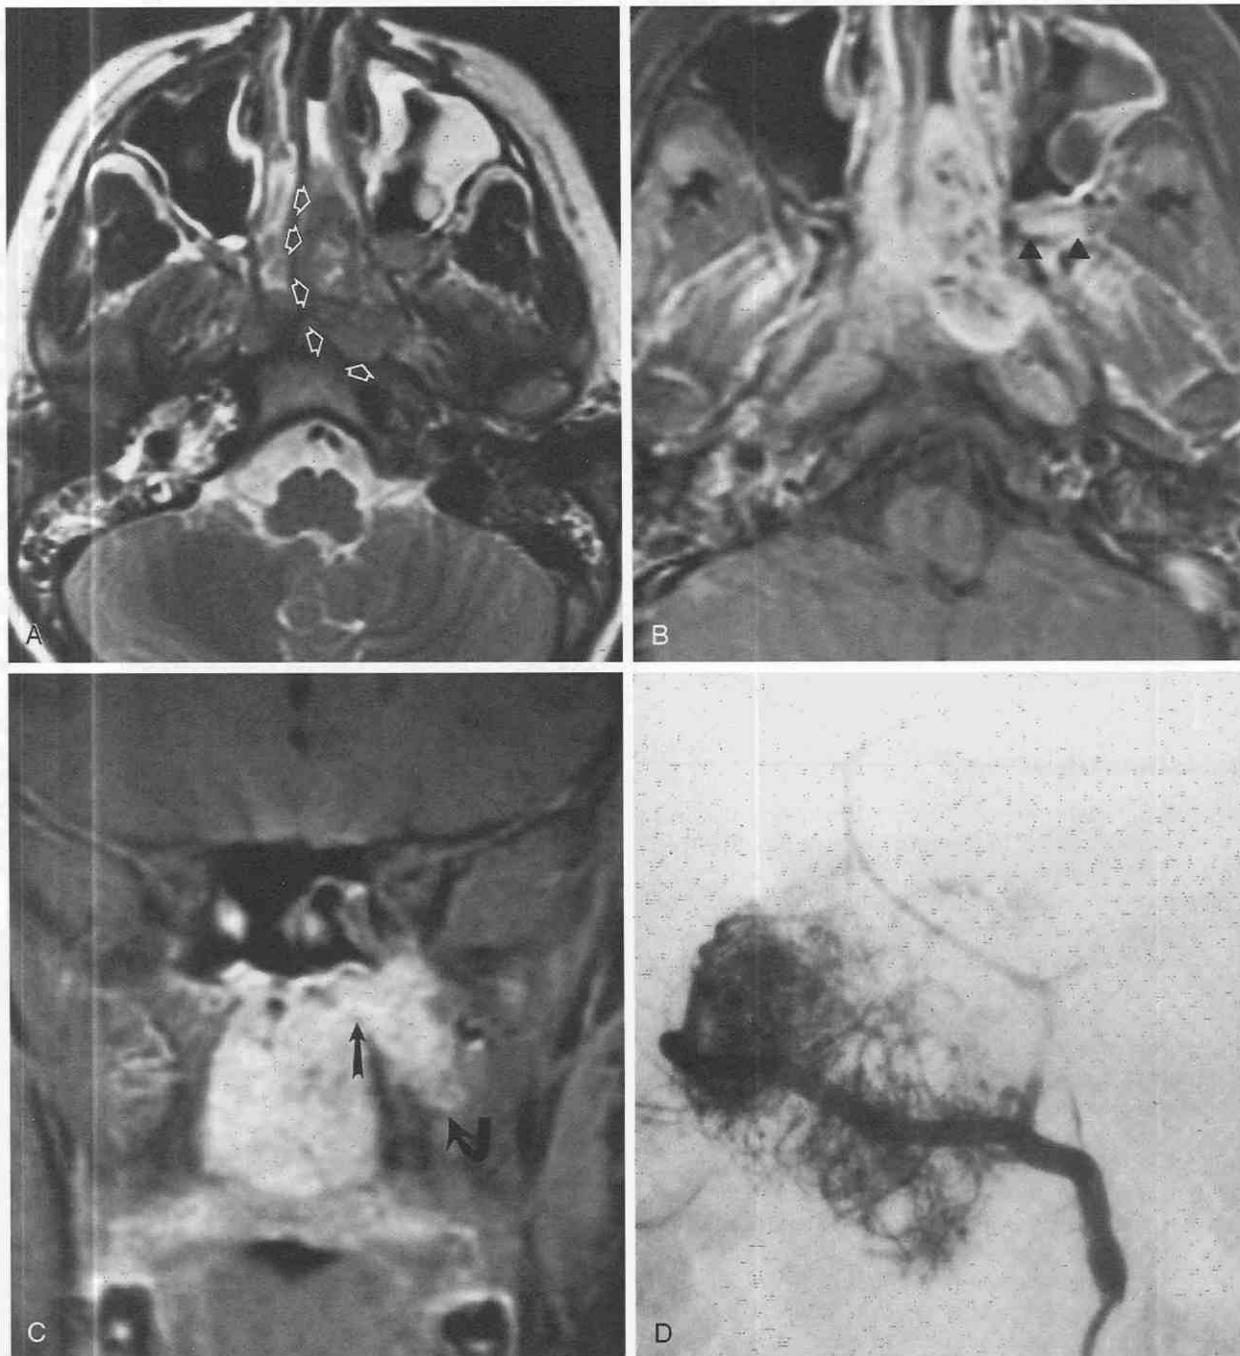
Juvenile nasopharyngeal angiofibroma. A, Axial T2-weighted MRI scan. The posterior nasal cavity and nasopharynx are expanded by a large mass of mixed-signal intensity (*open arrows*). B and C, Postcontrast axial (B) and coronal (C) MRI scans show flow voids within the mass (B), with extension through the sphenopalatine foramen (C) (*arrow*), the pterygopalatine fossa, and the pterygomaxillary fissure (B) (*arrowheads*) and into the infratemporal fossa (C) (*curved arrow*). D, Selective internal maxillary artery angiogram demonstrates multiple, tortuous, and hypertrophied branches supplying this nasal mass.
